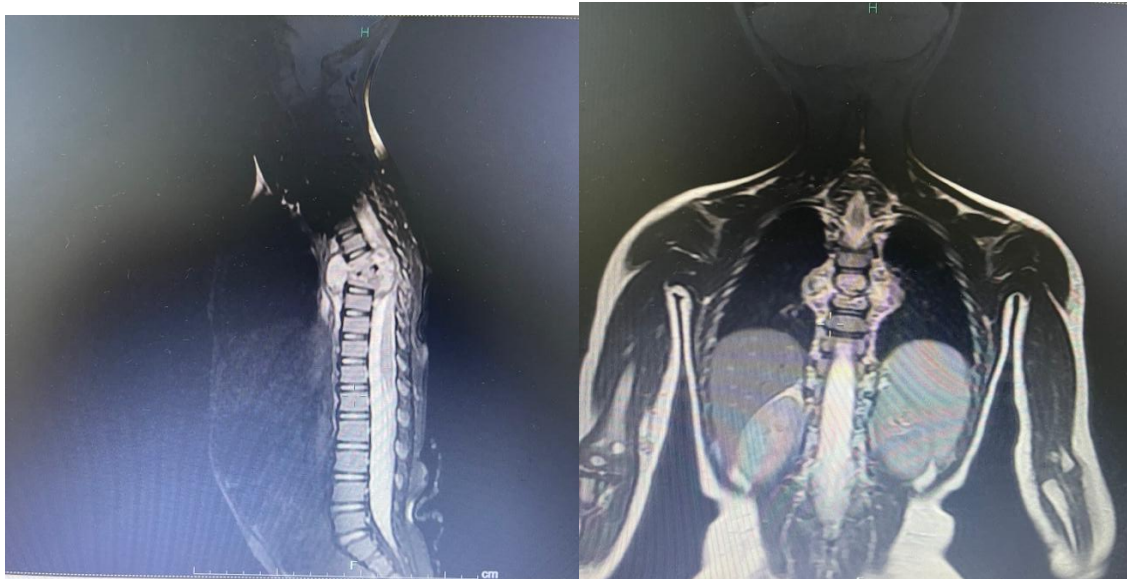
MRI Thoracal showing destruction of vertebral bodies at Thoracal 7 and Thoracal 8 with paravertebral abscess on the anterior and posterior that infiltrated the spinal canal and caused canal encroachment.
